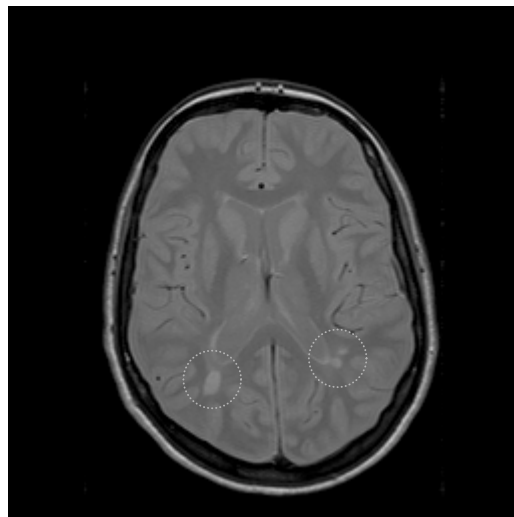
Axial slice of a P_D MRI of the brain of a patient affected by multiple sclerosis. Plaques have been marked with circles. Note that MS lesions appear as bright spots, whereas white matter shows dark intensities. This is due to the loss of myelin in the plaques.
